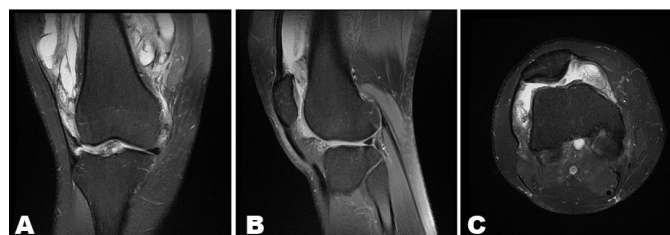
MRI study. (A) T2 Sagittal reconstruction, general synovial proliferation with nodular aspect. (B) T2 Coronal reconstruction, general synovial proliferation, with no bony erosion. (C) T2 Axial reconstruction, general synovial proliferation, occupying the femoropatellar space.
